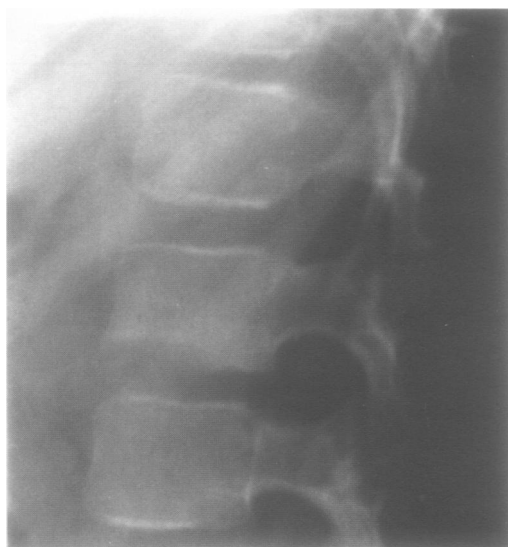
Coned lateral radiograph of the L2/L3 interspace 4 weeks later showing marked resorption of the inferior endplate of L2.
